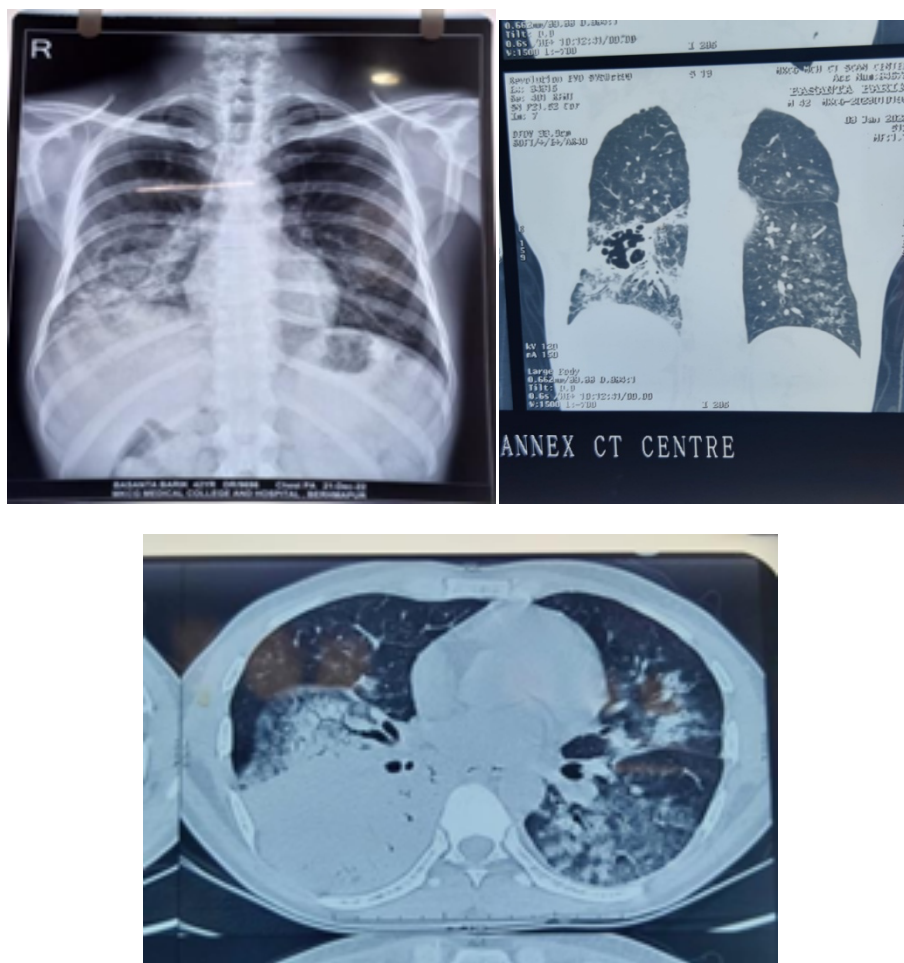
Chest X-rays and CT-scan of the patient showing bilateral ground glass opacities (B/L GGO) and consolidation with necrosis in the right lower lobe.
